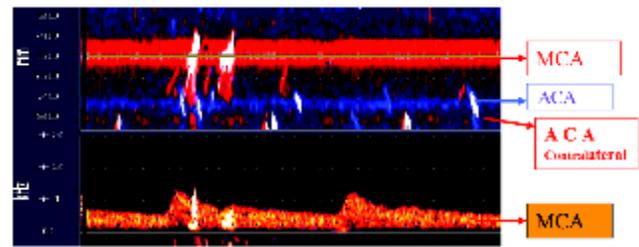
Embolic tracks (ETs) of bubbles on the power mode (upper panel) and microembolic signals (MESs) on the single-gate spectrogram of the middle cerebral artery (MCA; lower panel). The boxes to the right of the display, from the top downward, indicate 2 ETs in the MCA red band, 4 ETs in the ipsilateral anterior cerebral artery (ACA) blue band, 4 ETs in the contralateral ACA red band, and 2 MESs in the spectrogram also displayed as ETs in the MCA band. Note the single-gate Doppler detects only those bubbles passing the MCA while the power mode detects both ETs in the MCA and ETs in the ACAs. Time base = 2 seconds, stretched to accentuate the slopes of the ET.
